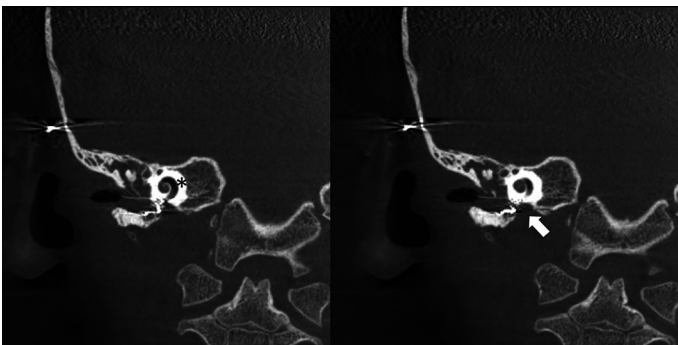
Coronal CT showing electrodes directed into internal carotid canal (white arrow) instead of the cochlea (asterix).
